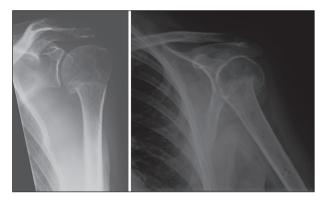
X-rays6 months after trauma.
